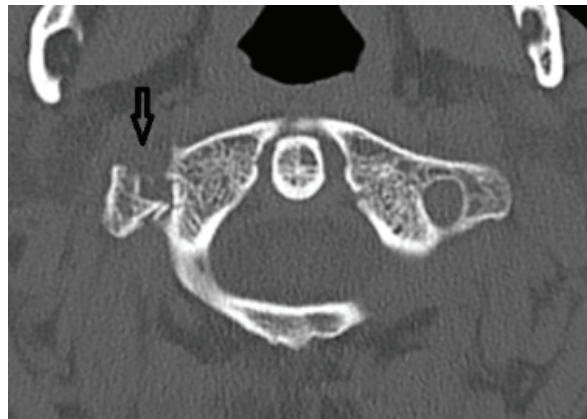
CT scan transverse section of cervical spine showing fracture of right transverse foramen of Atlas.
